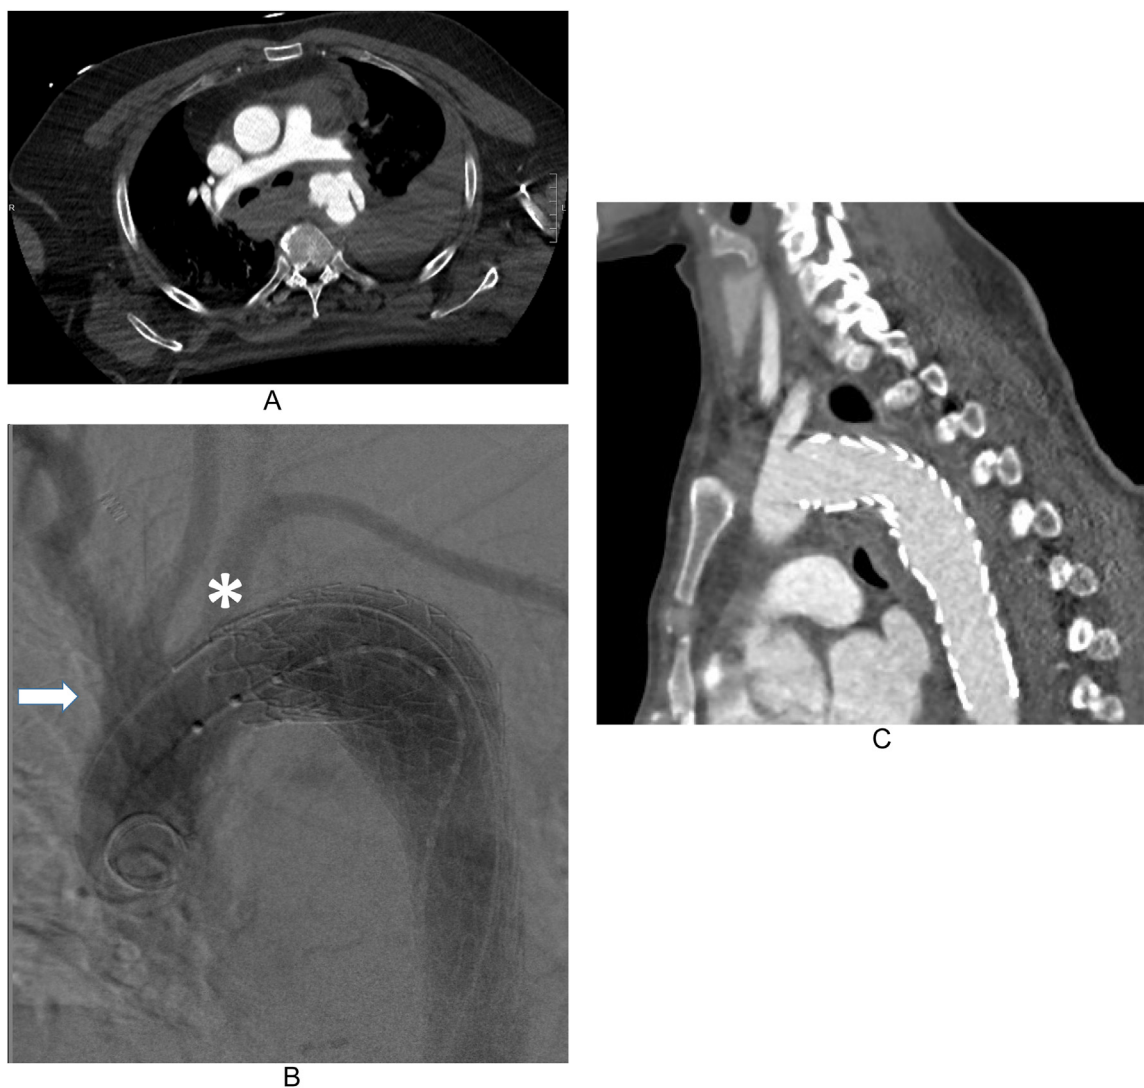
(A) Computed tomography angiography (CTA) chest with grade 3/4 blunt thoracic aortic injury (BTAI) with left hemothorax after high-speed mechanism. (B) Completion aortography with zone 3 thoracic endovascular aortic repair without evidence of endoleak. (C) Postoperative CTA chest at 6 months without evidence of endoleak and continued exclusion of BTAI.
